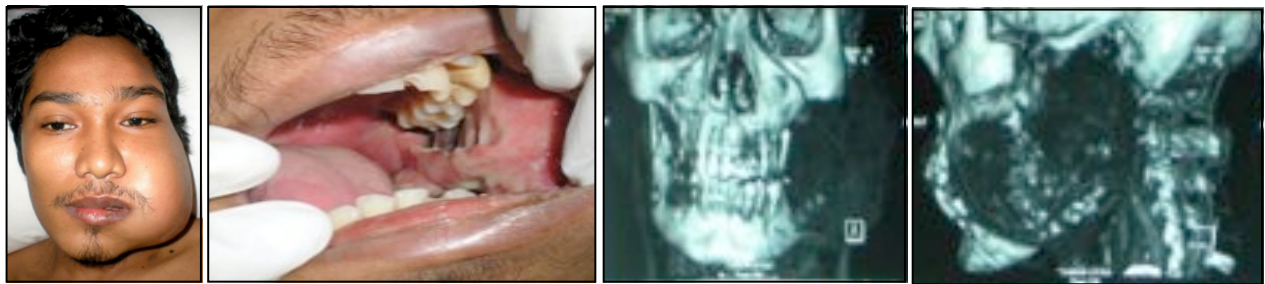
These are preoperative images of the patient. The frontal view and intra oral view of preoperative clinical images (upper row). Frontal and lateral view of the 3D CT scan showing the left mandibular destruction (Lower row).
